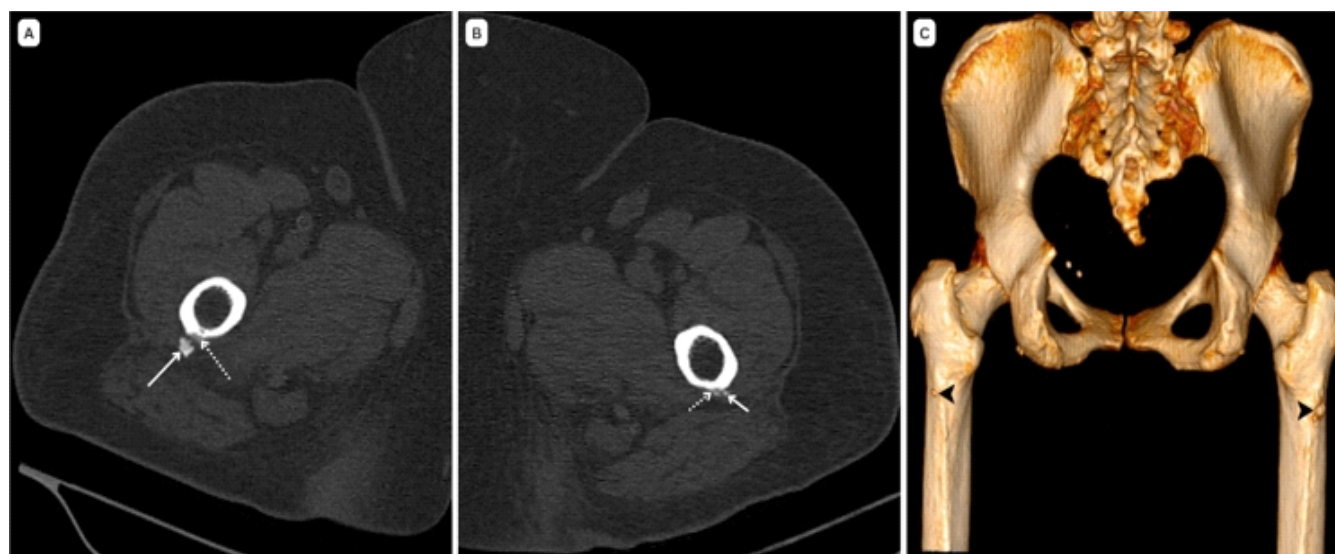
Axial computed tomography images of the right (a) and left (b) proximal femurs demonstrate amorphous calcific deposits (solid arrows) adjacent to the postero-lateral cortex at the level of the linea aspera, with mild associated cortical irregularity. Three-dimensional volume-rendered reconstruction (c) highlights bilateral calcific foci (arrowheads) at the linea aspera. The left-sided calcific deposit is significantly smaller than the one on the right side.
